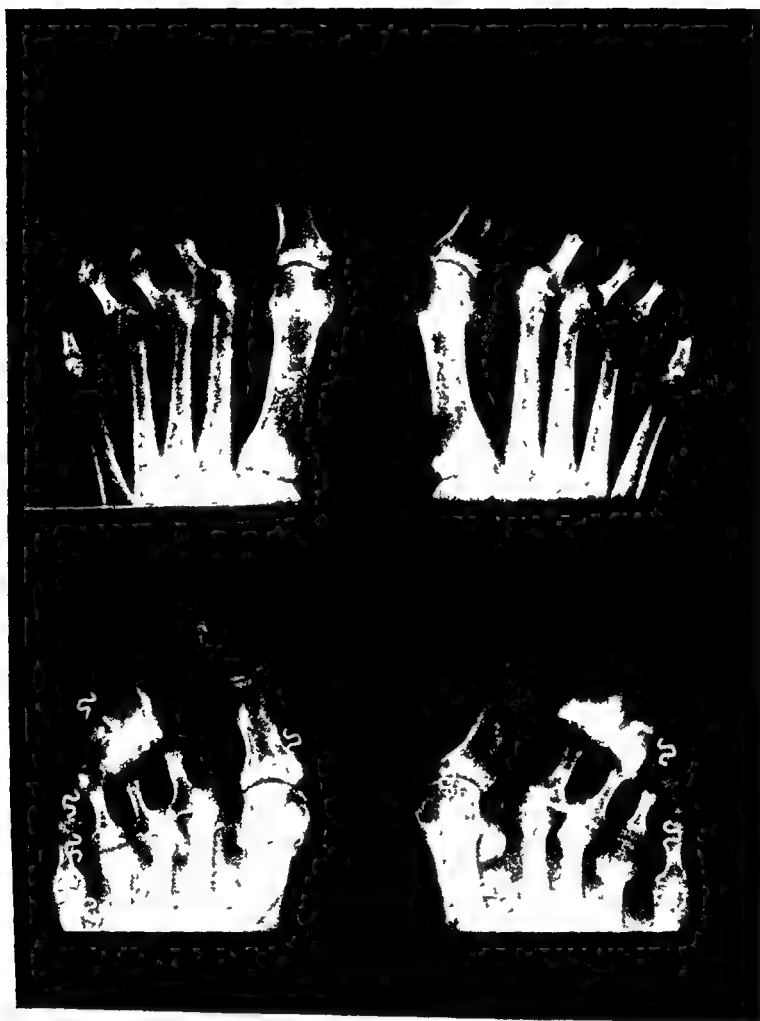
RADIOGRAPH OF RHEUMATOID ARTHRITIC CASE Observe particularly the metatarsophalangeal subluxations of the second and third toes of left foot. The lower section shows the same case shod and a flexible plastic toe retainer applied to assist in toe purchase. Note the improvement in the second and third metatarsophalangeal joints of left foot. The flexible plastic toe retainer is visualized as an area of increased density under the interphalangeal joints.
